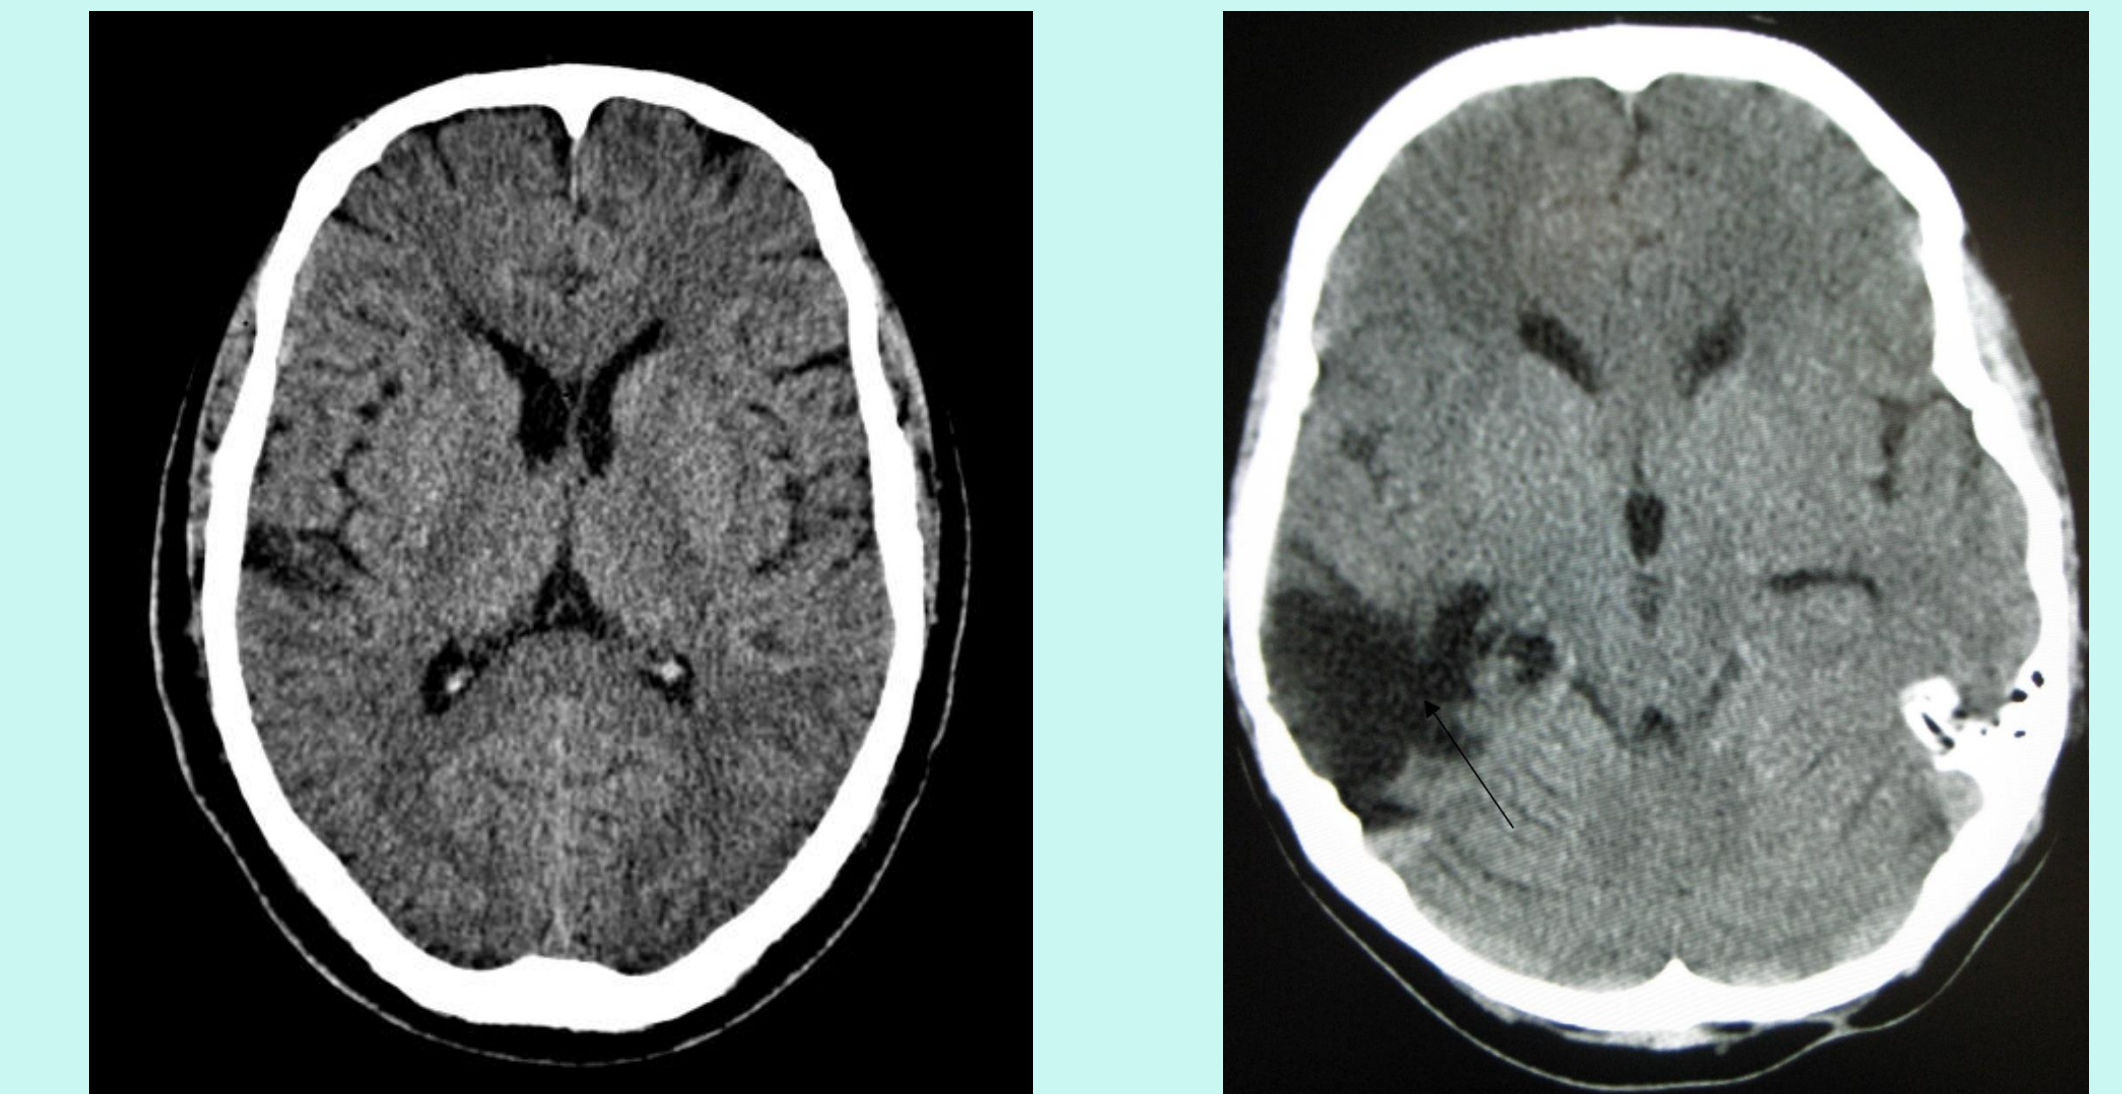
Representative Images for a normal brain CT scan (left) and a subarachnoid hemorrhage (right).
